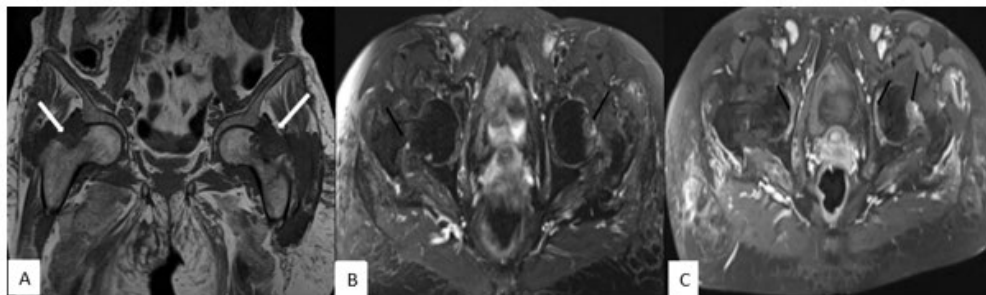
Pelvic MRI images in coronal T1 sequence (A), axial T2 (B), and axial T1 FAT SAT after Gadolinium injection showing bilateral periarticular pseudo-masses with T1 hypointensity, slight heterogeneous T2 hyperintensity, and mild heterogeneous enhancement after Gadolinium injection. Additionally, there are geodes in the femoral necks with heterogeneous T2 hyperintensity, along with thickening of the articular synovium, which is enhanced after Gadolinium injection, consistent with amyloid deposits.
